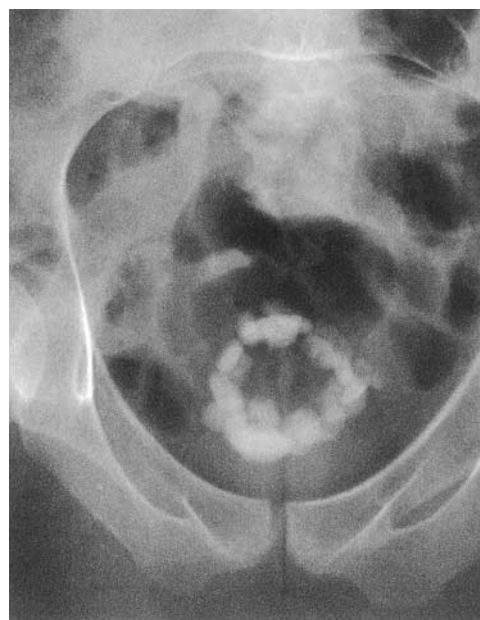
X-ray of abdomen, taken on 15 March 2002, shows two larger radio opaque calculi in the bladder
